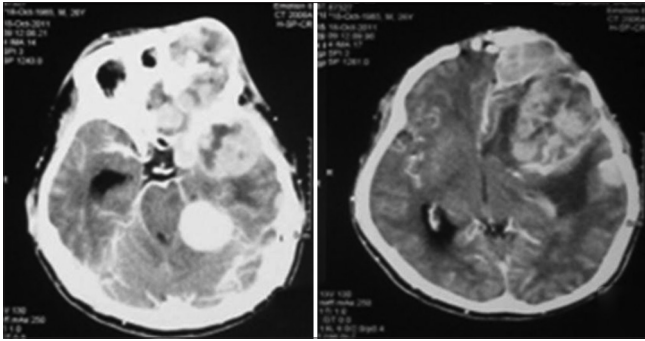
Computed tomography scan post gadolinium contrast showed multiple hyperdense extraaxial enhancing masses
